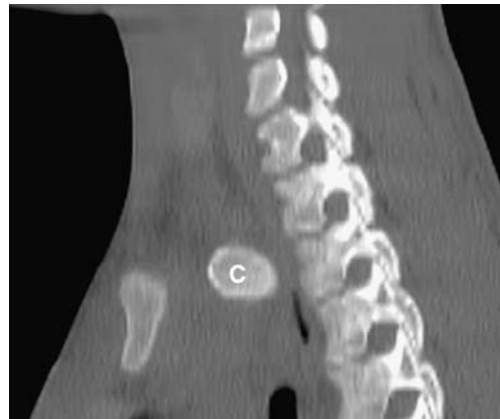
CT, sagittal reconstruction. Note the posteriorly displaced medial end of the right clavicle (*C*). Note how it compresses the airway posterior to it and how close it lies to the vertebral column
